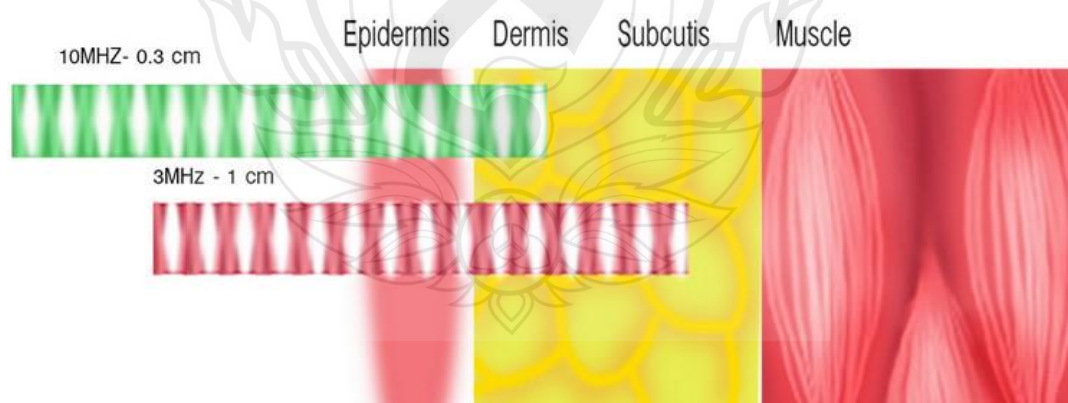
Penetration depth of Dual Frequency Ultrasound
